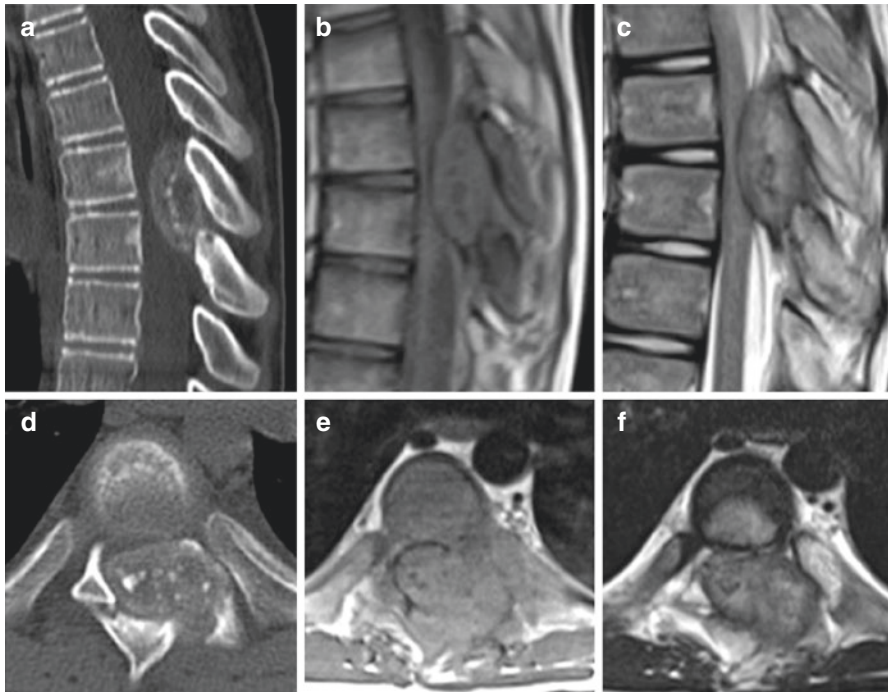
(a–f) Osteoblastoma in the posterior elements of a thoracic vertebra, incidentally found in a young patient on a CT investigation after trauma (a, d). The tumour extends into the spinal canal and has a calcified or ossified matrix. On MRI an isointense signal is seen on T1-WI (b, e) and a heterogeneous iso- to hyperintense signal on T2-WI (c, f)
